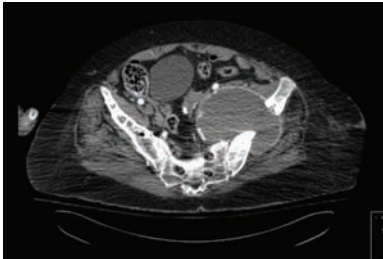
CT scan demonstrating large fluid collection displacing pelvic vessels
